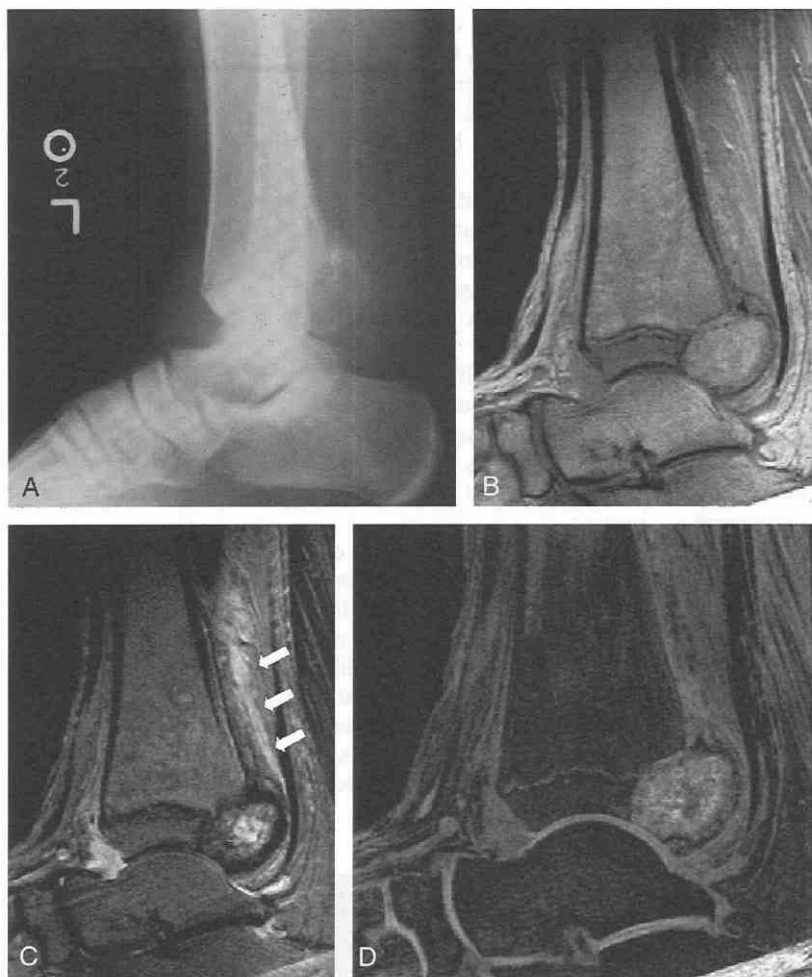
Chondroblastoma in a 16-year-old boy. *A*, Lateral radiograph demonstrates an expansile mass arising from the back of the tibia. *B*, Sagittal T1-weighted image shows that the mass is purely epiphyseal in this nearly skeletally mature patient. *C*, Sagittal T2-weighted image shows heterogeneous bright and isointense signal intensity within the mass as well as edema of the adjacent musculature (arrows). *D*, Sagittal cartilage-sensitive (fat-suppressed 3D gradient-echo) sequence yields signal intensity within this cartilage tumor that is nearly as bright as in the nearby articular hyaline cartilage.
